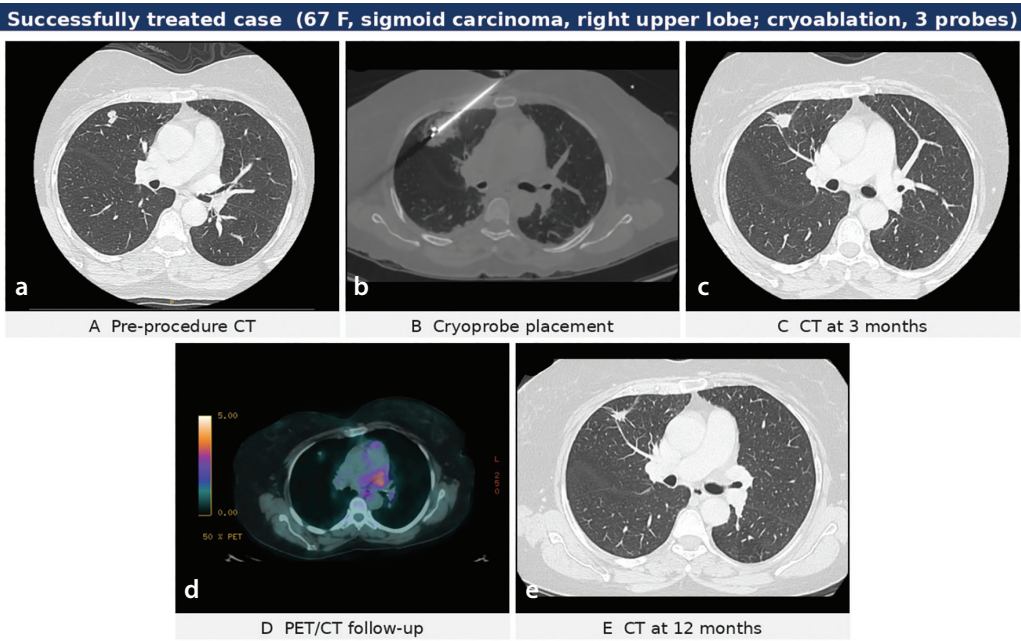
Successful computed tomography (CT)-guided cryoablation of a right upper lobe metastasis (sigmoid carcinoma) with complete metabolic response and durable local control to 12 months. (a) Pre-procedural axial CT demonstrating a right upper lobe pulmonary metastasis. (b) Intraprocedural CT demonstrating accurate placement of cryoprobes within the lesion prior to cryoablation. (c) Follow-up contrast-enhanced CT at 3 months demonstrated the expected post-ablation changes, with no residual enhancement. (d) FDG PET/CT at 6-month intervals demonstrating complete absence of metabolic activity within the treated lesion, consistent with complete response. (e) CT chest obtained 12 months after cryoablation, demonstrating a stable post-ablation scar without evidence of local recurrence. FDG, fluorodeoxyglucose; PET, positron emission tomography.
